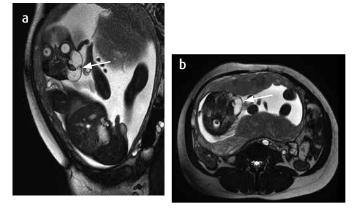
MRI. a) Sagittal with T2 information; b) axial with T2 information. Patient of 25.4 weeks. Injury to the facial soft tissues, with a multisepted cystic component (arrow), with a diameter of 4.0 cm \times 3.6 cm \times 4 cm, well defined margins, without area compression.
